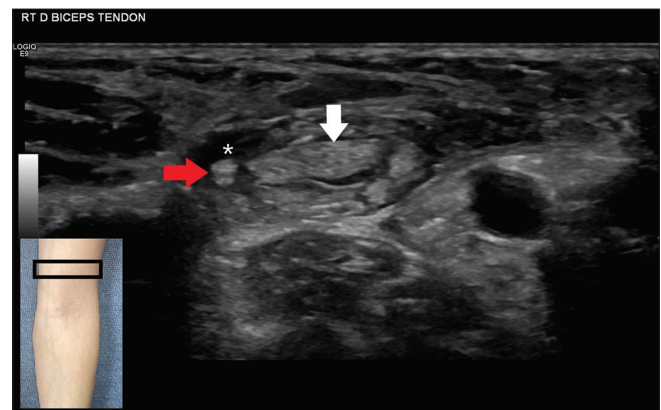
Transverse ultrasound image of the distal biceps tendon. Thickened and ruptured distal biceps tendon (white arrow) with surrounding hematoma (asterisk). Intact accessory distal biceps tendon (red arrow) could be identified separately, with movement on dynamic forearm supination and pronation
